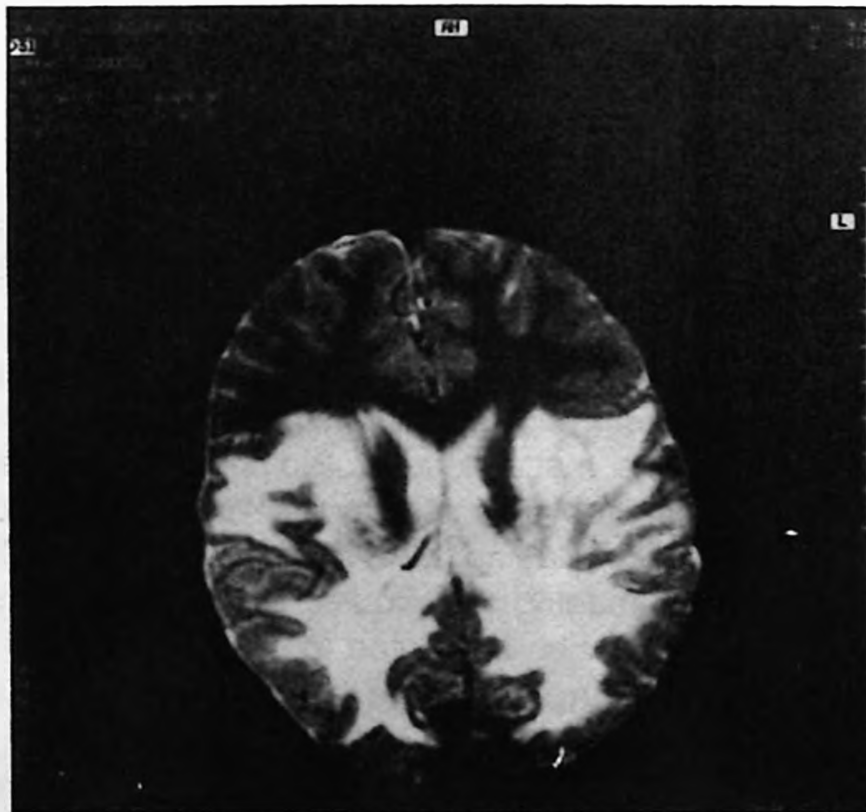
High-intensity symmetrical signal of parieto-occipital white matter on MRI. The lateral and medial geniculate bodies, corpus callosum splenicum and lateral lemniscus were involved.
